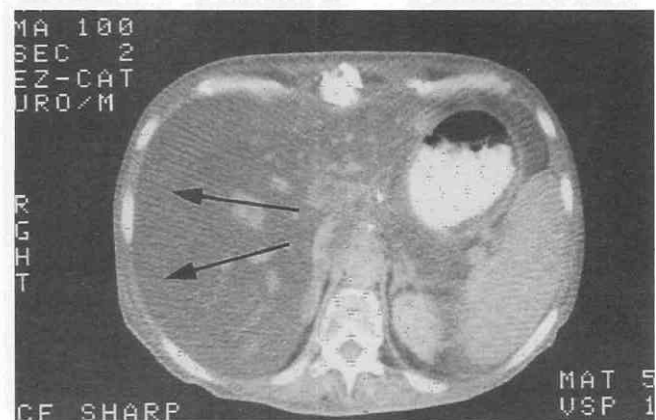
CT scan shows a fatty liver, which has a perihepatic fluid collection. It is difficult in some cases to see the adjacent fluid next to the liver capsule (arrows).
